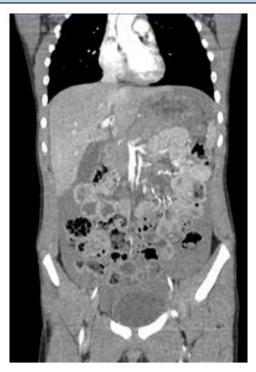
Edema of the jejunum in the left hemiabdomen. Discrete inhomogeneity of the lateral arm of the left adrenal gland and pancreas tail edema most likely by type of contusion The CT finding on other organs of the abdomen was unremarkable except of free bulky fluid consist with haemorrhage in abdomen and pelvis.
